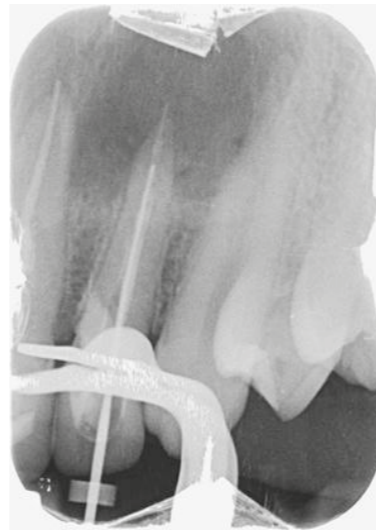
Working length periapical radiograph of tooth 22.
